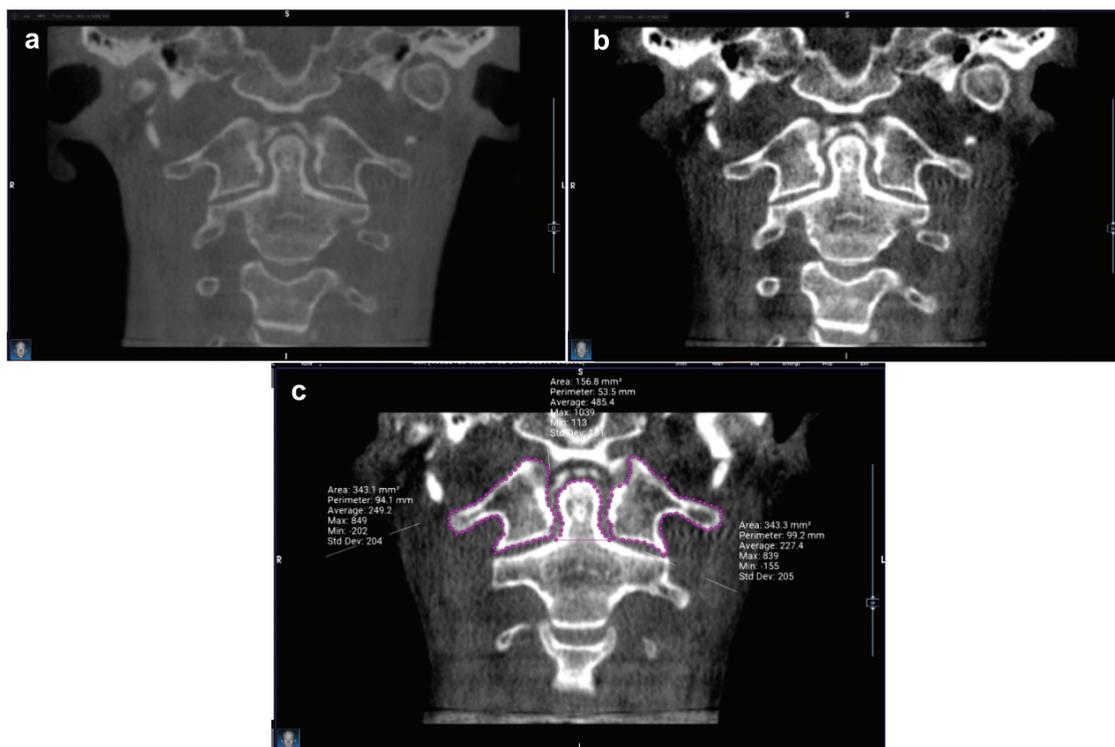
(a) Coronal cone beam computed tomography (CBCT) slice at default window width and window level of the software. (b) The same slice as seen using the adjusted window width and window level to increase the contrast of the image and differentiate bone from other tissues. (c) Outlines of the regions of interest and where the measurements were made.
